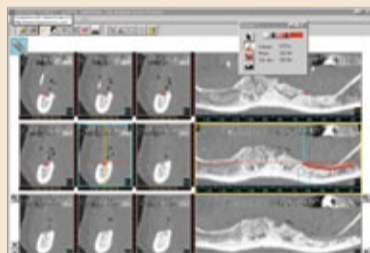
CT scans can show problems such as the ID nerve being at the crest of the ridge
